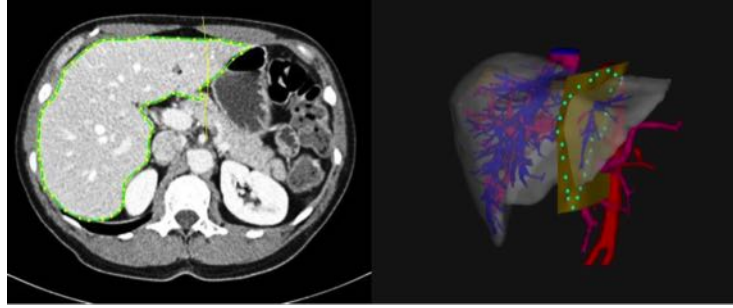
Example of a preoperative plan from Scout Liver software. Left: Preoperative CT image with segmented boundary of the liver in green. Right: Visualization of segmented liver showing the hepatic (red) and portal (blue) vasculature branches. The planned resection plane (yellow) divides the tumor (brown) from the healthy liver remnant. Images reproduced from [21].
